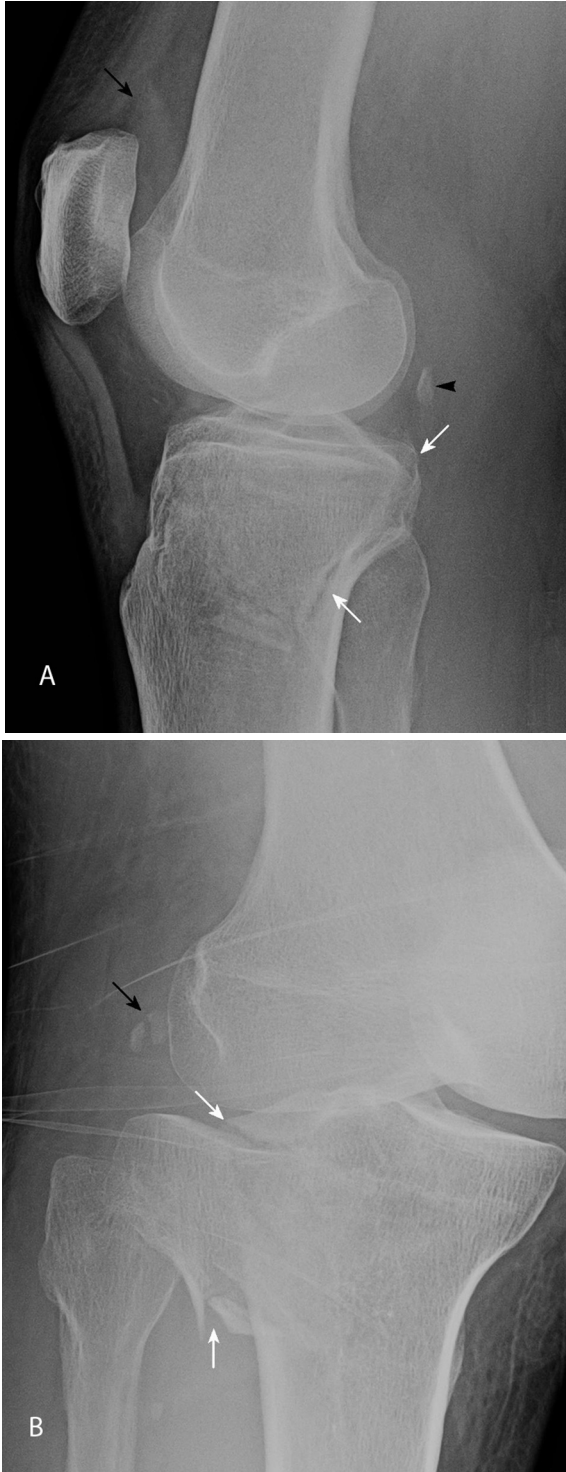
65-year-old man with fracture of the fabella. Lateral and oblique radiographs of the right knee. A. Lateral view shows an effusion (black arrow) and the tibial plateau fracture (white arrows). The fracture line through the fabella (arrowhead) is not visible on this view. B. Oblique view shows a vertical, mildly displaced fracture of the fabella (black arrow). The split-depression fracture of the lateral plateau is better visualized (white arrows).
